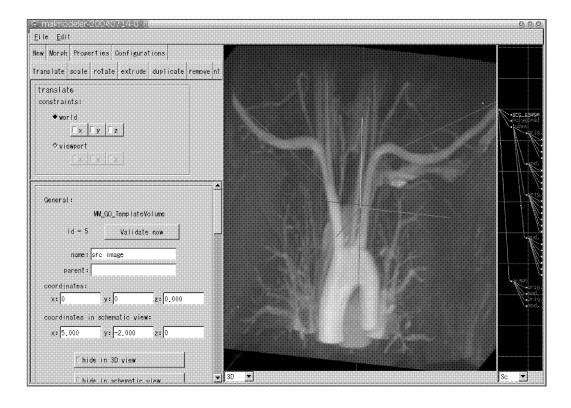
The CFD model is examined against the original volumetric MRI data to adjust minute shape to the real one.
